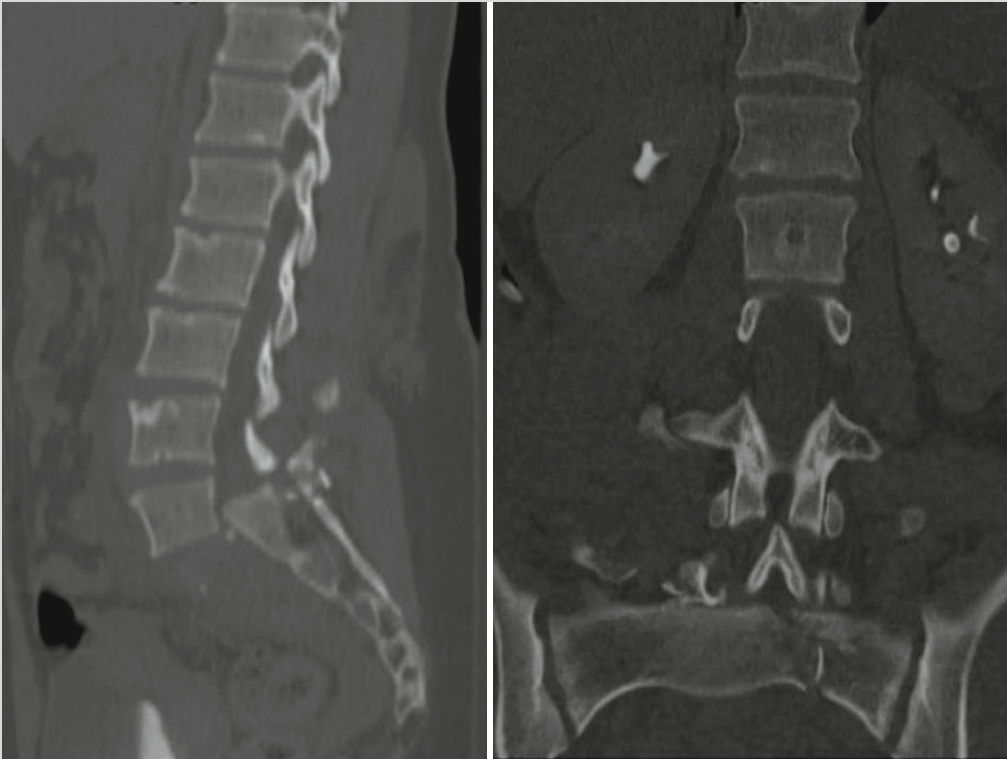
Midsagittal and coronal computed tomography (CT) images of the lumbosacral spine demonstrating severe traumatic disruption of the lumbosacral
